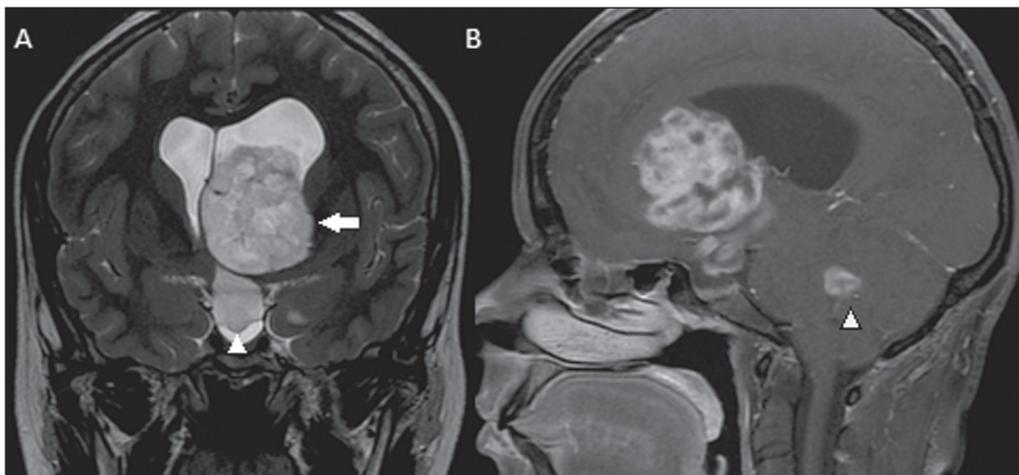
Coronal T2-weighted MRI sequence (A) and contrast-enhanced sagittal T1-weighted MRI sequence (B) showing a lesion with discretely elevated signal intensity on the T2-weighted sequence and heterogeneous contrast enhancement throughout the left lateral ventricle (arrow), extending through the foramen of Monro to the third ventricle (arrowhead in A). In the sagittal acquisition, the lesion can also be seen within the fourth ventricle (arrowhead in B).
